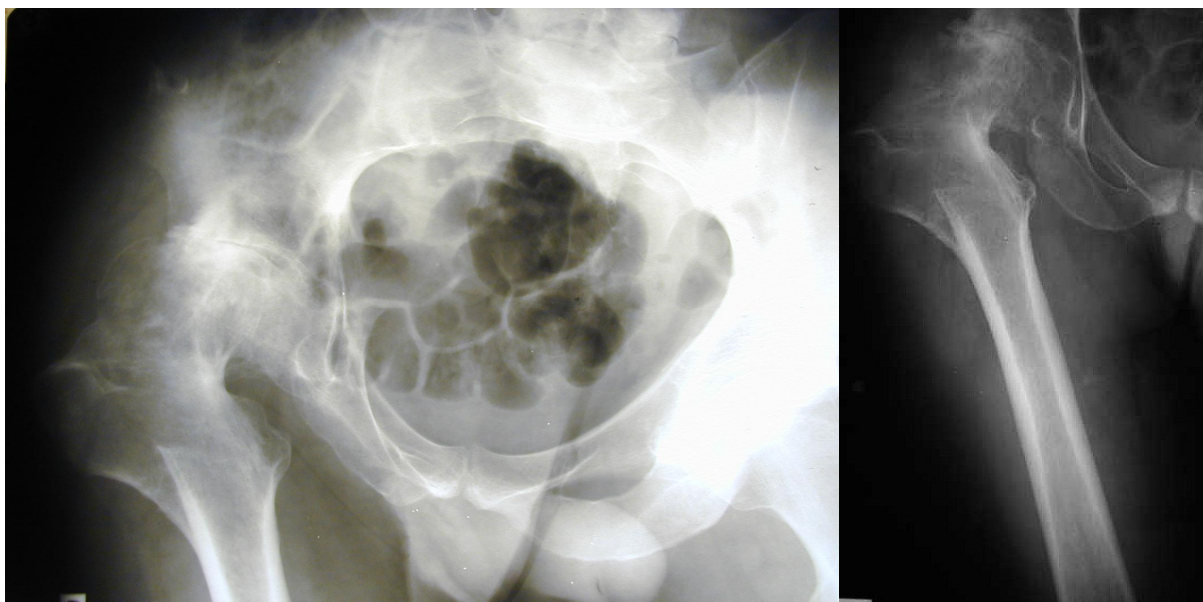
X-ray films of male patient M., angle $\beta = 23^\circ$.
